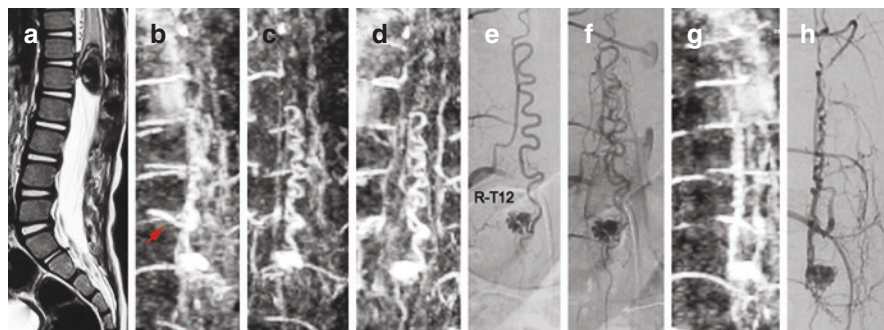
A case of pediatric PMAVF (3-year-old boy). (a) Plain T2 WI MRI image (sagittal view), indicating ball-like vessel dilation with space-occupying effect at T12–L1 vertebral body level. (b–f) MRA indicates that the feeding artery is located at one segment above the dilated vascular ball. The location and morphology of the feeding artery are consistent with that in the DSA image. (g–h) MRI and DSA (lateral view) show that the feeding artery is ventral to the spinal cord. *DSA* digital subtraction angiography, *MRA* magnetic resonance angiography, *PMAVF* perimedullary arteriovenous fistula, *WI* weighted image
